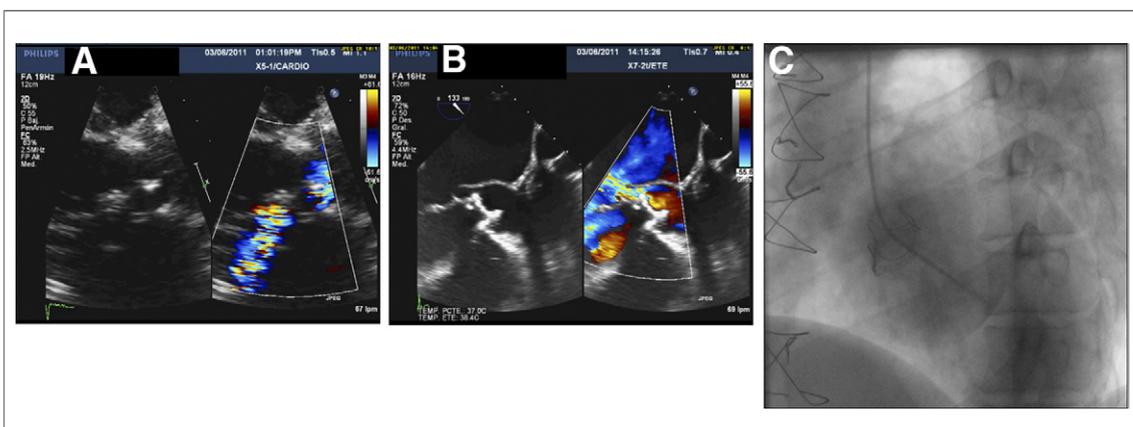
Diagnostic Work-Up: Echocardiogram and Angiography
